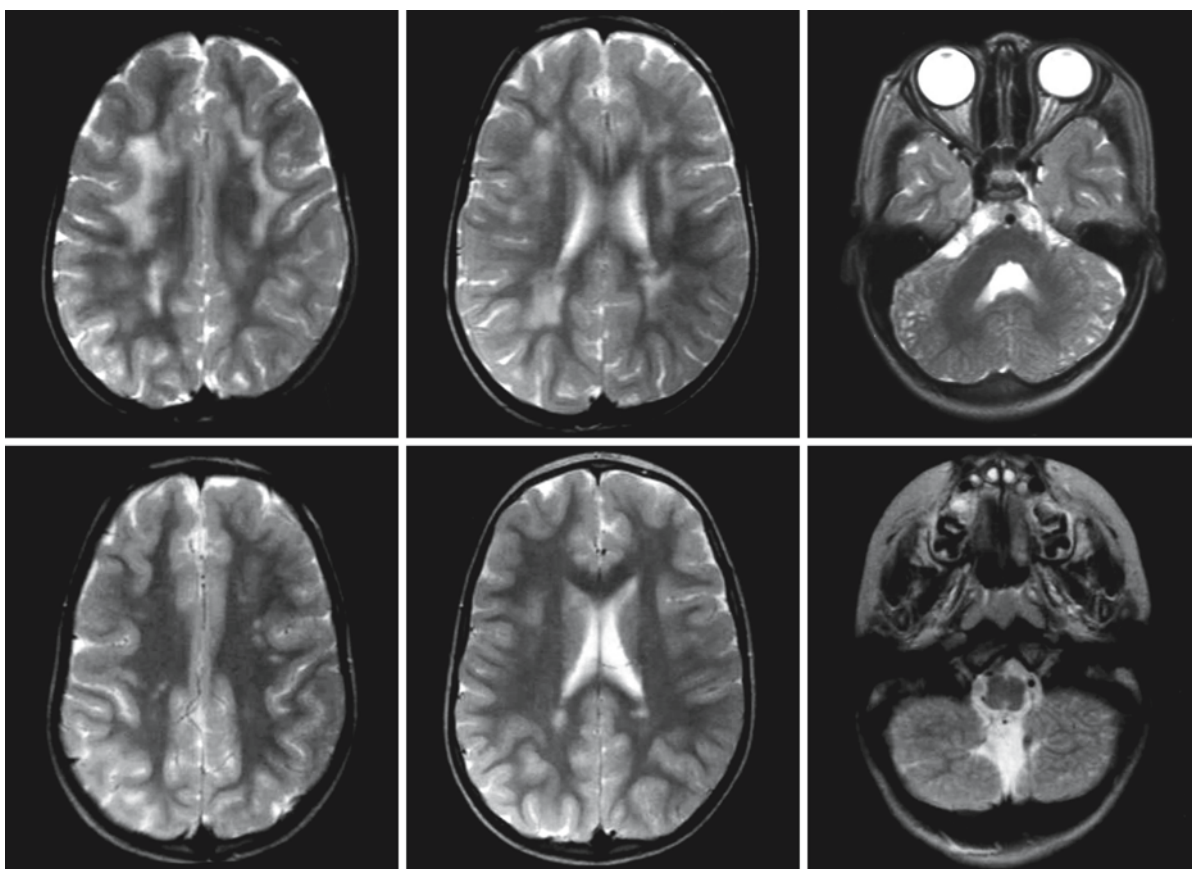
A girl with MDC1C. The first MRI (*first row*) was obtained at the age of 3 years; the follow-up MRI (*second row*) at the age of 6 years. The initial MRI shows multifocal large white matter lesions, mainly involving the deep white matter. On follow-up, most white matter abnormalities have disappeared and only a few foci of abnormal signal remain. The cerebellar
